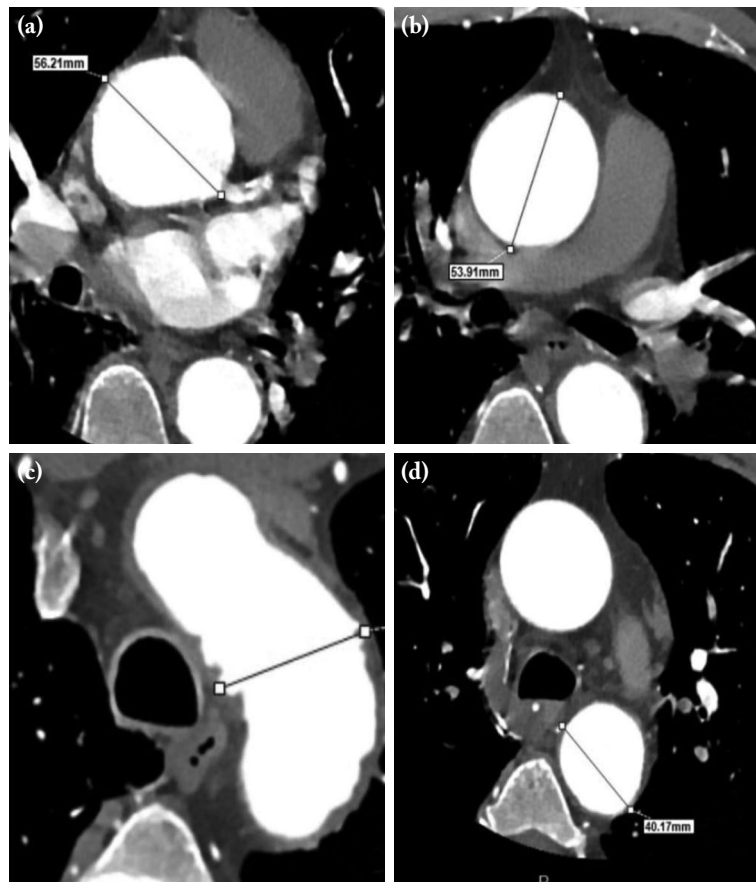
Contrast-enhanced computed tomography scans. (a) Aortic root. (b) Ascending aorta. (c) Aortic arch. (d) Descending aorta.
